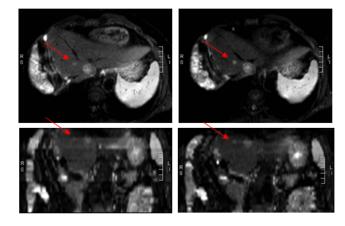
Slices (upper row) and MPR (lower row) acquired with a DWI sequence on 1.5 T using RBT (left) and VBNT (right).
